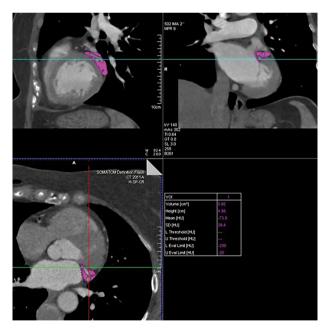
Computed tomography slice shows how the left atrioventricular groove epicardial adipose tissue volume was measured in sagittal, coronal, and axial views, and the table shows the numeric values
